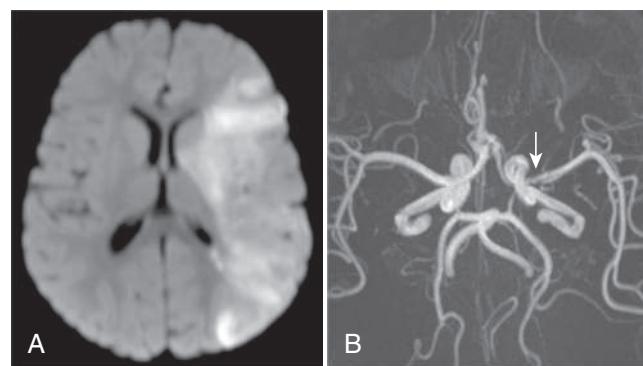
A, Axial diffusion-weighted magnetic resonance imaging demonstrating hyperintense signal in the left middle cerebral artery distribution consistent with acute infarct. B, Magnetic resonance angiography axial maximum intensity projection images demonstrating narrowing of the left middle cerebral artery M1 segment (arrow). (From Vora SB, Amlie-Lefond C, Perez FA, et al. Varicella-associated stroke. *J Pediatr*. 2018;199:281, p. 281.)
